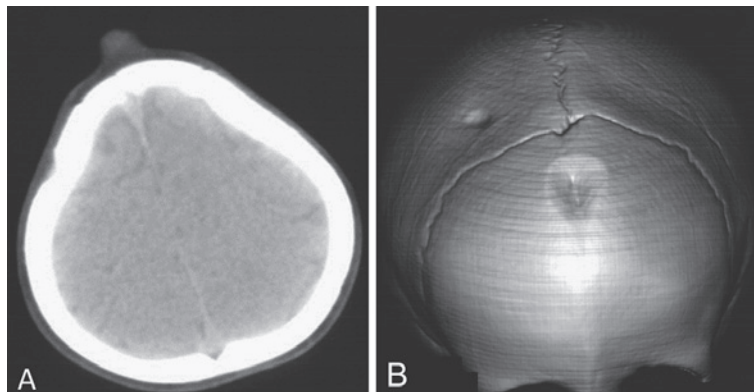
A) CT after fontanelle closure, showing the tumor with unchanged size. B) Three-dimensional CT showing depression of the frontal bone where the tumor is located.
